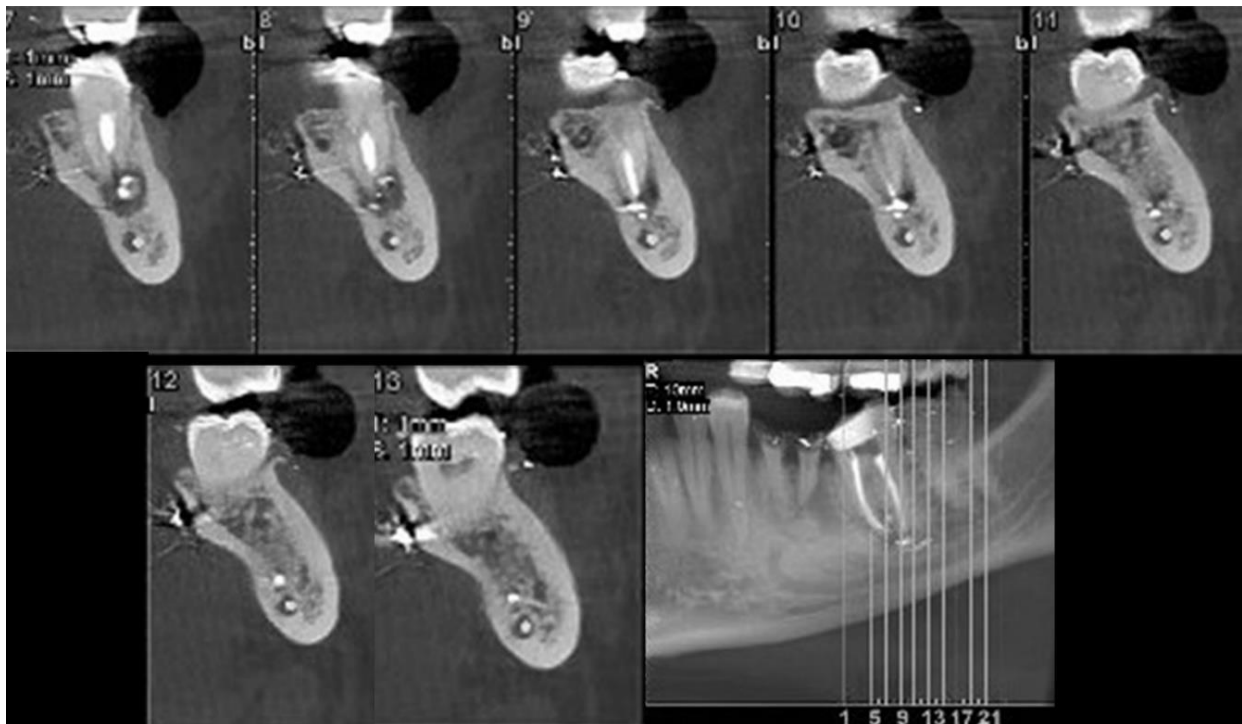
Post-operative CBCT images showed that sealer penetrated the sub-branches of the mandibular canal
